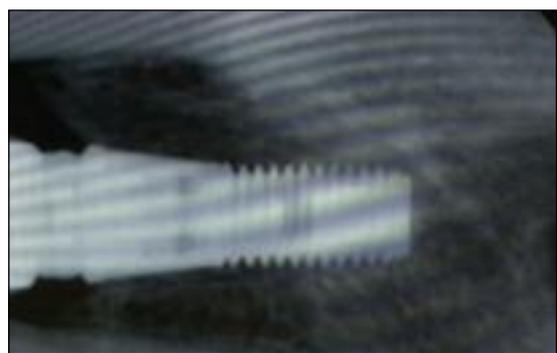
The radiograph at fit
